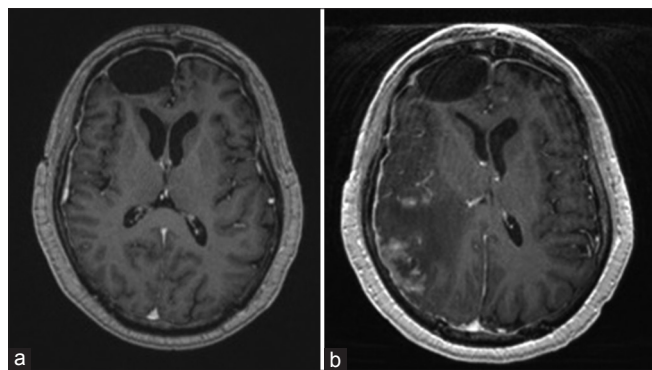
(a) MRI T1W with contrast four-weeks post-surgical evacuation of subdural collection and initiation of platinum-based chemotherapy demonstrating marked improvement. (b) MRIT1W with contrast eight-weeks following initiation platinum-based chemotherapy demonstrating marked progression of invasive tumor in the right parietal and posterior frontal lobes, extensive vasogenic edema extending to the atrium of the right lateral ventricle and midline shift
